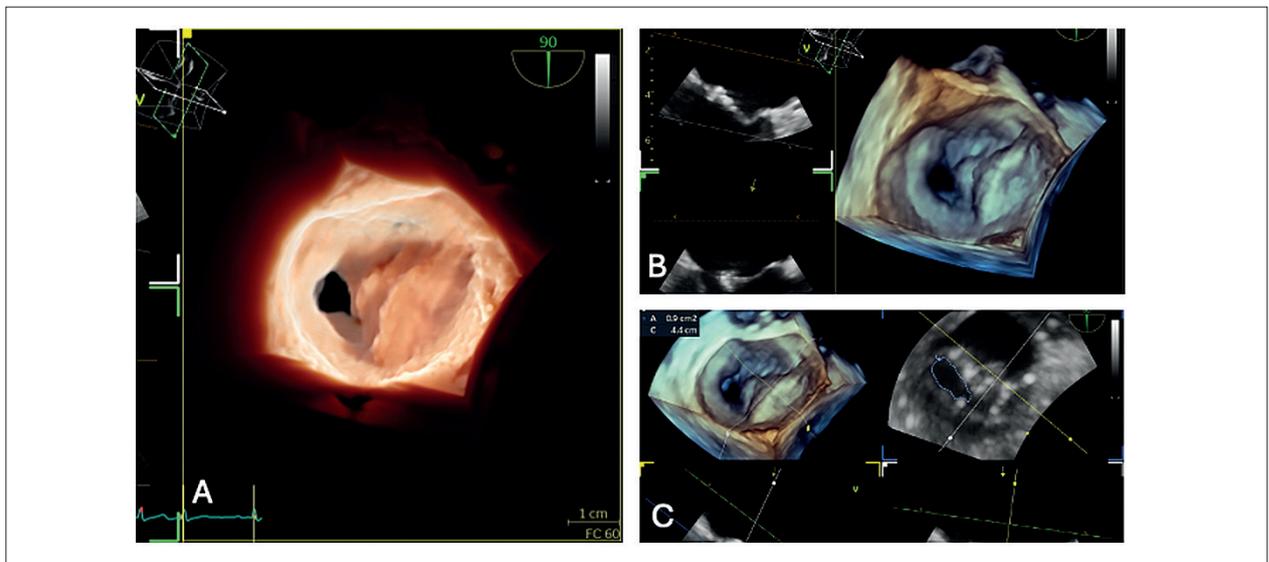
Images obtained by three-dimensional transesophageal echocardiography demonstrating partial commissural fusions and asymmetric calcification in rheumatic mitral stenosis. (A) Transillumination image, highlighting extensive calcification and asymmetric fusion of the posteromedial commissure. (B) Three-dimensional en face view of the mitral valve, highlighting the fusion and asymmetric distribution of calcium between the commissures. (C) Three-dimensional transesophageal planimetry showing severe stenosis.
